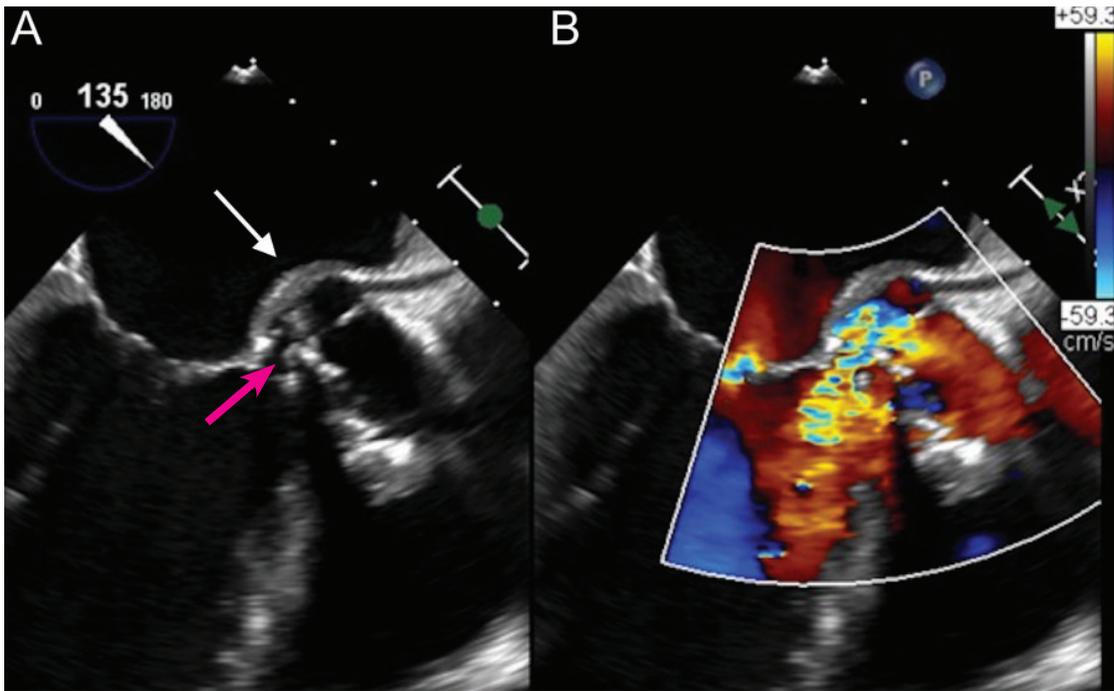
(A) Transesophageal echocardiography, mid-esophageal long-axis view, demonstrates a prominent aortic root abscess cavity (white arrow) posteriorly in a patient with a prosthetic aortic valve. Also note partial dehiscence of the aortic bioprosthesis (red arrow). (B) Color Doppler analysis demonstrates significant aortic regurgitation between the aortic bioprosthesis and the left ventricular outflow tract through the prominent abscess cavity.
